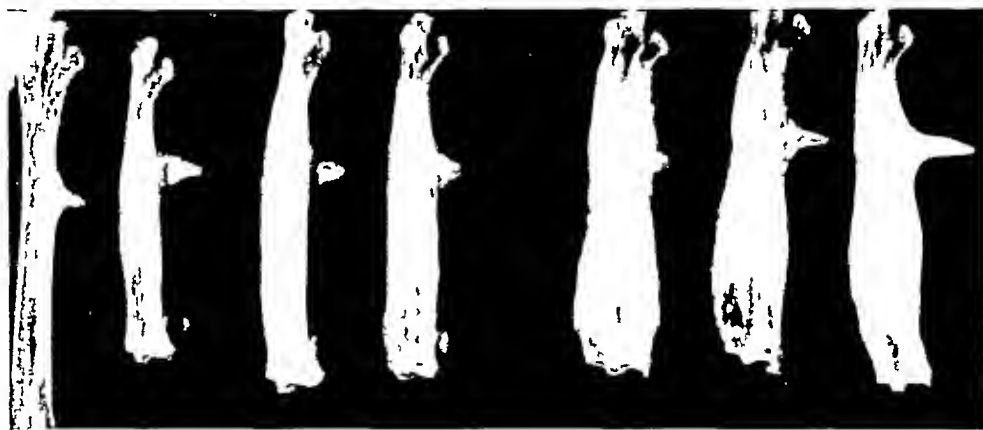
Roentgenograms of metatarsi of osteopetrotic birds, normal bone on left
